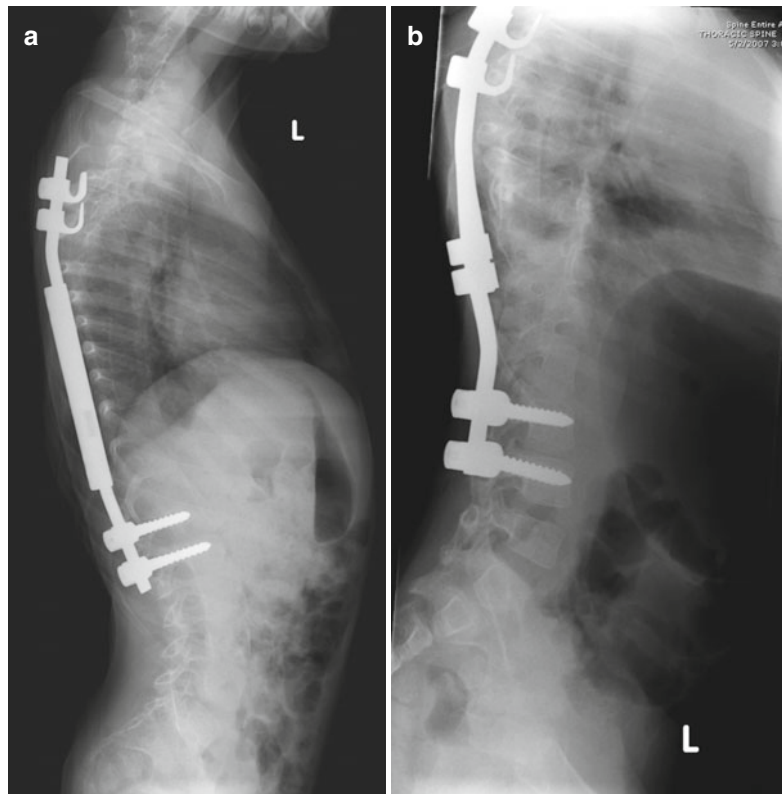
(a) Lateral view of a longitudinal connector. (b) Lateral radiograph demonstrating a side-to-side connector with physiological sagittal contouring of rods (Reproduced with permission of Children’s Orthopaedic Center, Los Angeles)
